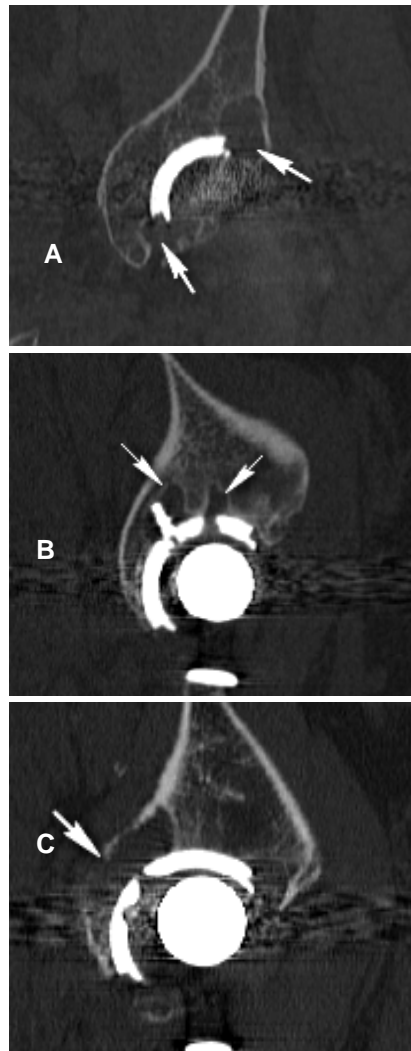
Coronal and sagittal CT images showing (A) rim-related, (B) hole-related and (C) combined osteolytic lesions (indicated by arrows) adjacent to H-G acetabular components.
